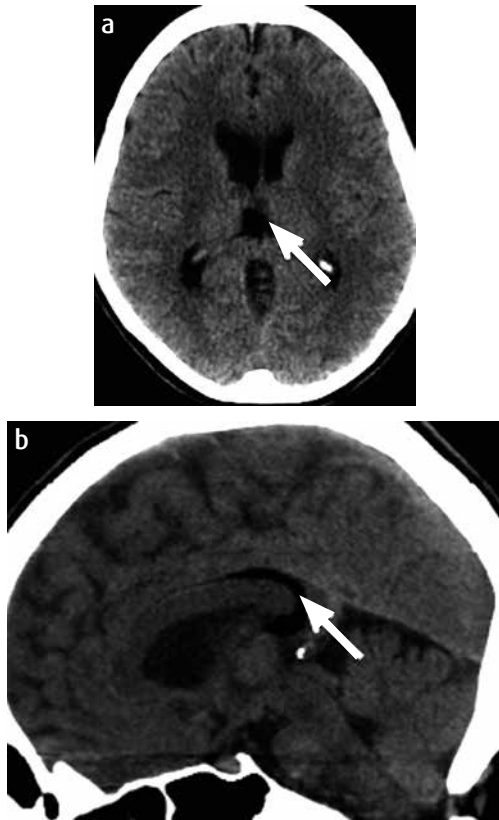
CT. a) Axial slice and b) sagittal reconstruction. Low density image, third of fat, localized in the splenium and posterior part of the corpus callosum compatible with lipoma (arrow).
